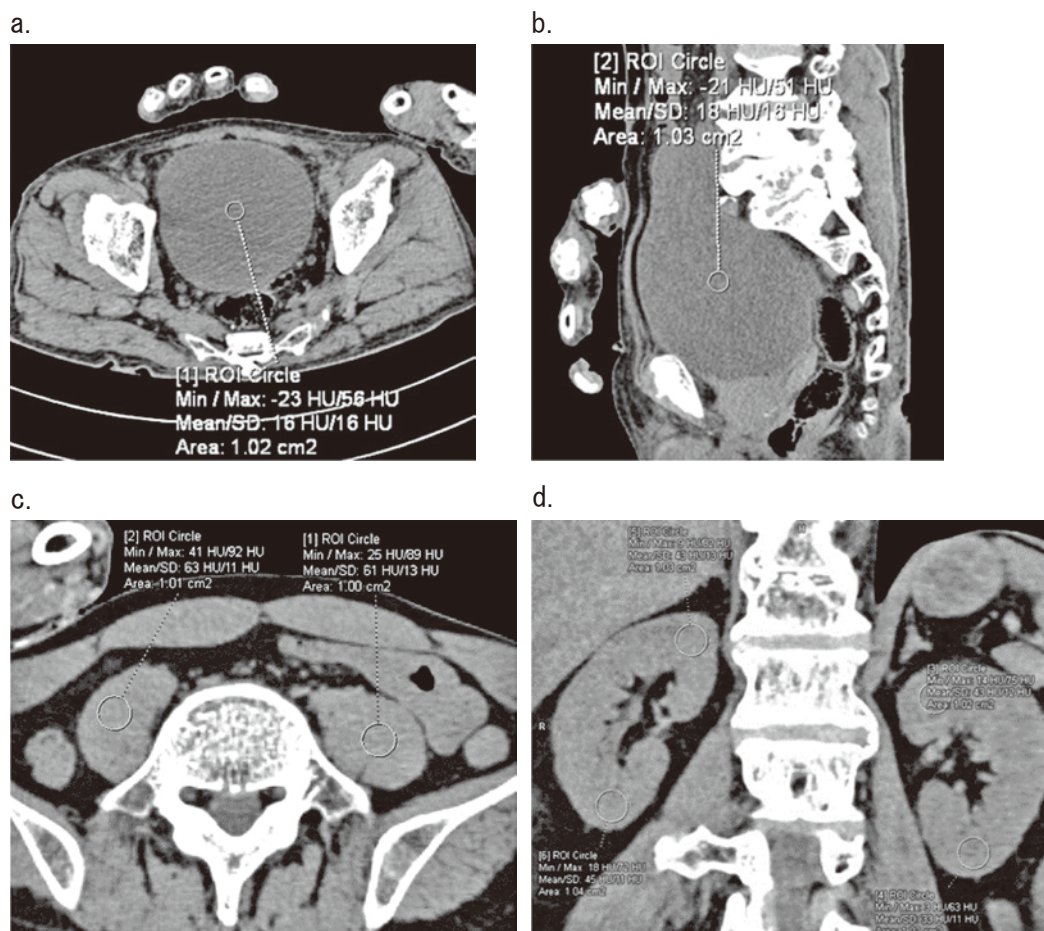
Hounsfield unit value measurements in postmortem computed tomographic images of horizontal section urine (a), sagittal section urine (b), the iliopsoas (c), and the kidney (d).
